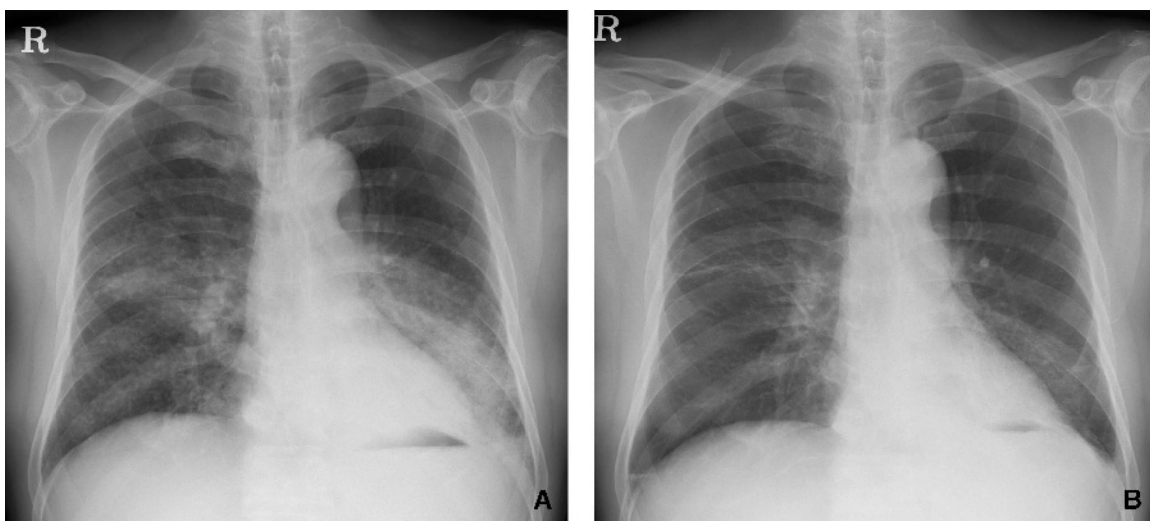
Chest radiography of a 73-year-old man who showed a rapid response to gefitinib. After the diagnosis of bronchiolo-alveolar cell carcinoma, the patient received two cycles of cytotoxic chemotherapy, but progression was noted (A). Within a week of gefitinib treatment, rapid and marked resolution of infiltrates and bronchorrhea were observed (B).
